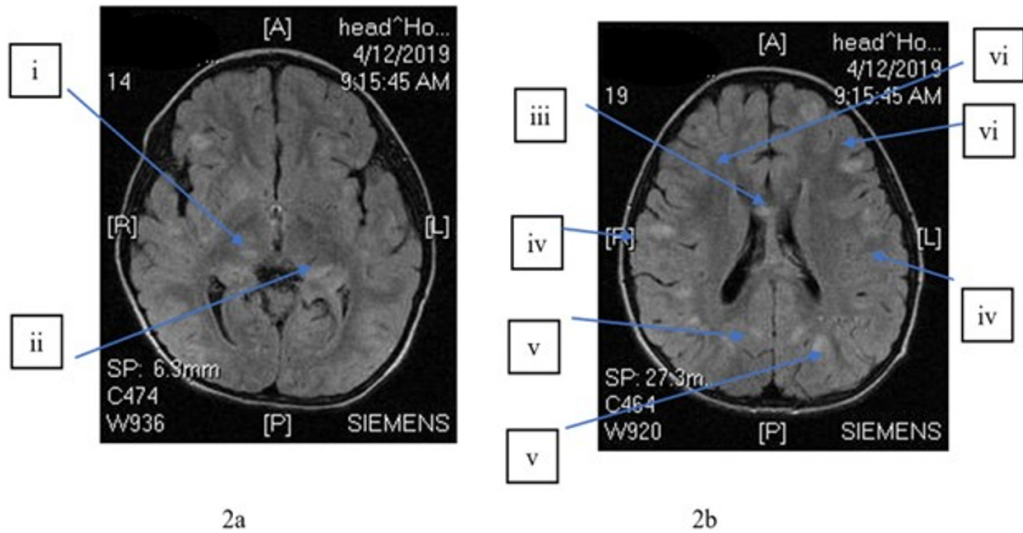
MRI T2/FLAIR of the brain shows disseminated asymmetrical white matter hyperintensities
